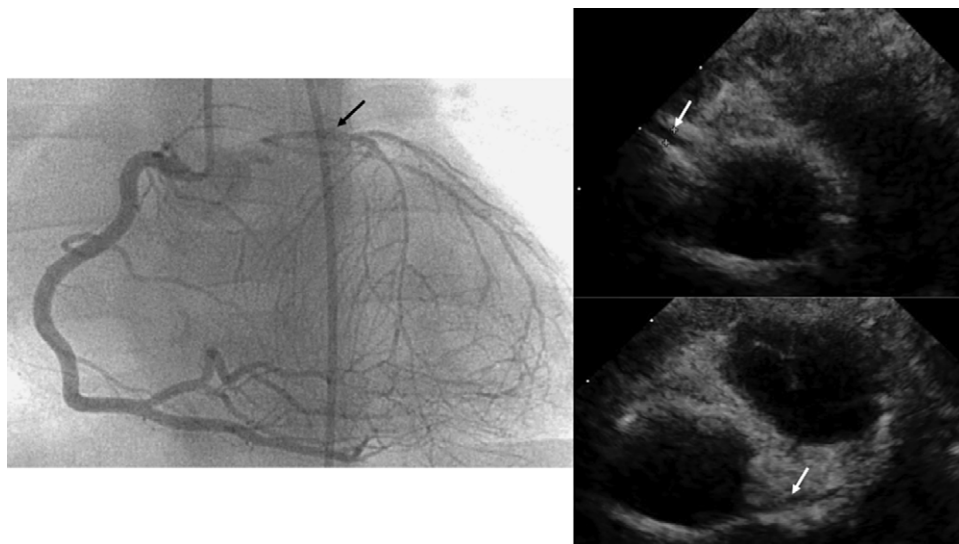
Coronary angiogram and echocardiograms before the operation (Patient 2) (Left) Right coronary angiograms at the age of 1 year and 6 months (Patient 2) (Right upper) Right coronary artery (Right lower) Left coronary artery The diameters of the right coronary artery and the left anterior descending artery were 1.9 mm and 1.7 mm, respectively.
